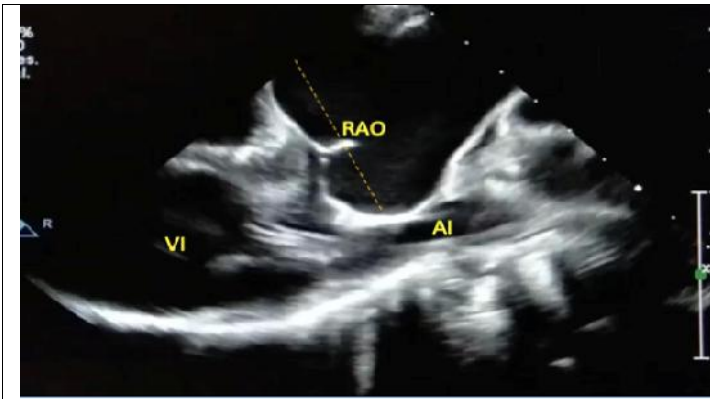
Aortic root dilation, 46 mm (sz + 12) by echocardiography
